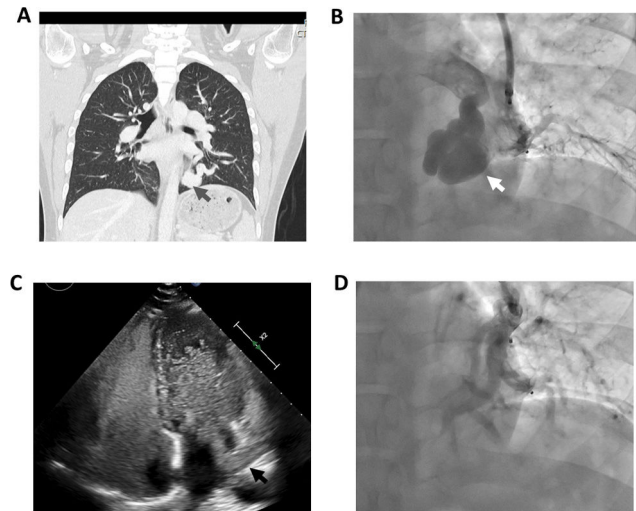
Imaging of the pulmonary arteriovenous malformation. An initial thoracic CT revealed (A) dilated and tortuous pulmonary arteries and veins that joined together in a nodule of 32 mm in the left lower lung lobe consistent with a pulmonary arteriovenous malformation (gray arrow); this was also confirmed during pulmonary angiography (white arrow, B). A transthoracic contrast echocardiography with agitated saline was performed. After ten cardiac cycles, countless saline bubbles were observed traveling through the left inferior pulmonary vein (black arrow) into the left atrium (C) without a Valsalva maneuver suggestive of significant right-to-left shunt. It also showed dilated right ventricle, systolic flattening of the interventricular septum and increased tricuspid regurgitation velocity. The pulmonary arteriovenous malformation was treated via vascular plug closure (D).
